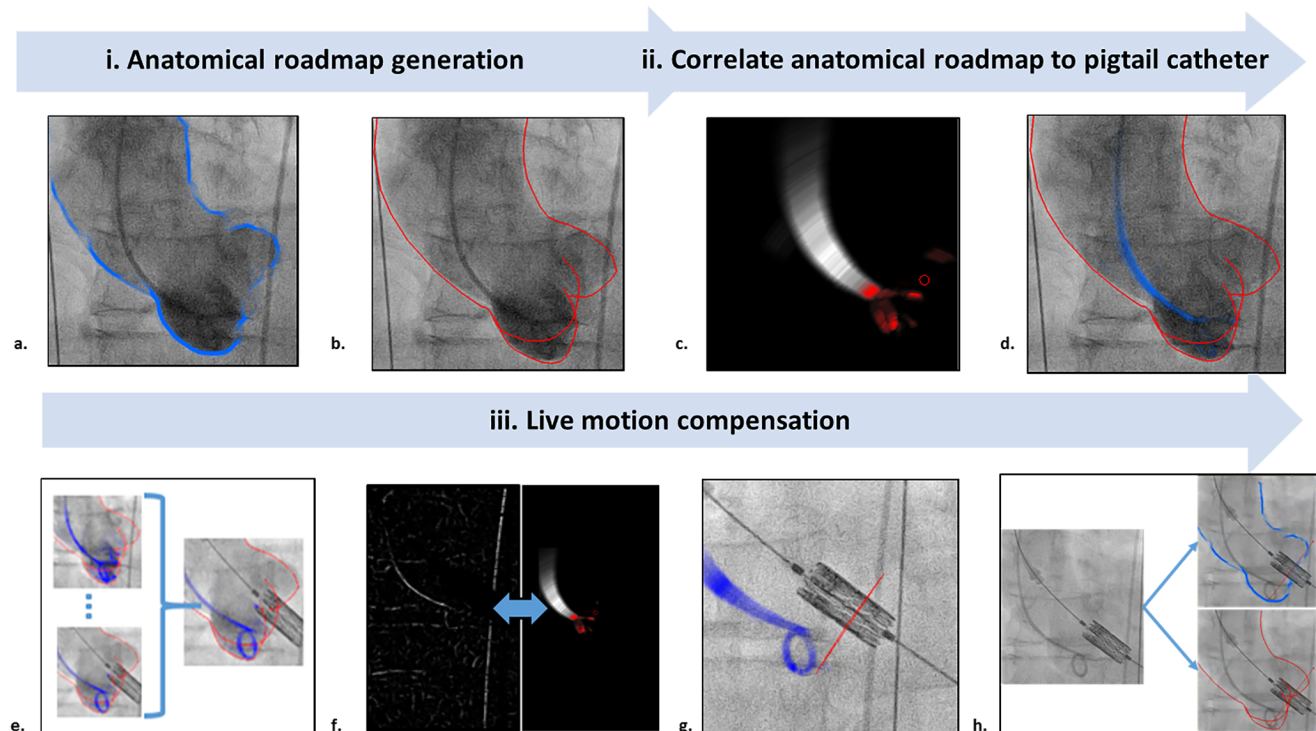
The three steps of motion compensation: i. Anatomical roadmap generation: (*Panel A*) Vascular Outlining (VO) based on the angiographic image, (*Panel B*) Computed-Tomography (CT) segmentation registered to the angiographic image. ii. Correlate anatomical roadmap to pigtail catheter: (*Panel C*) The reference map for the pigtail is extracted, (*Panel D*) The spatial relation between the pigtail reference map (*blue*) and the anatomical roadmap (*red*) is set. iii. Live motion compensation: (*Panel E*) The pigtail reference map best matching the current pigtail shape is selected, (*Panel F*) Live fluoroscopic image is filtered (*left*) and matched to the pigtail reference map (*right*), (*Panel G*) Fluoroscopic view of the matching result, (*Panel H*) The transformation is applied to the anatomical roadmap resulting in a dynamic motion-compensated roadmap, either VO (*blue*) or CT (*red*).
